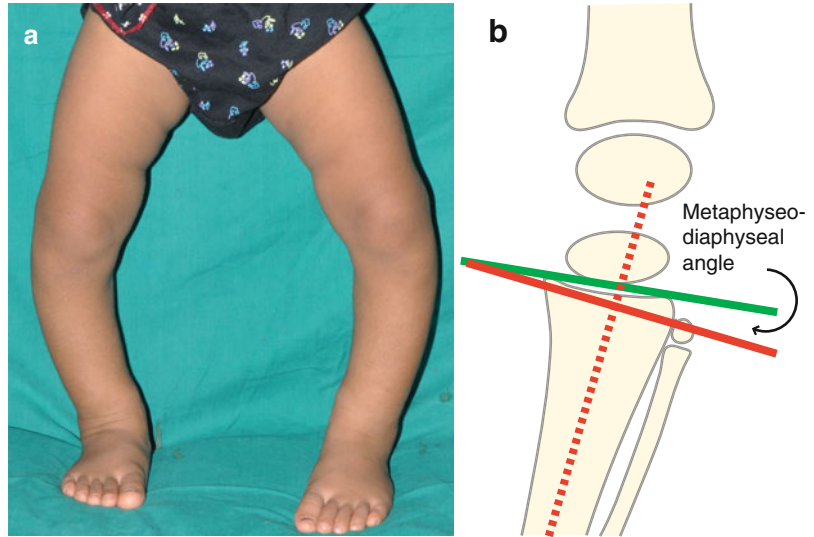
The measurements that are made on full-length standing radiographs of the lower limbs taken with the patellae facing forward
